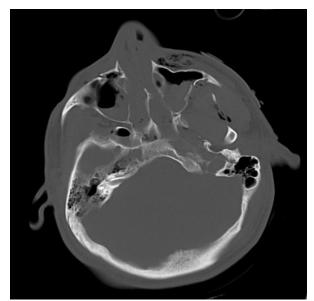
Head CT showing multiple extensive maxillary facial and orbital fractures
